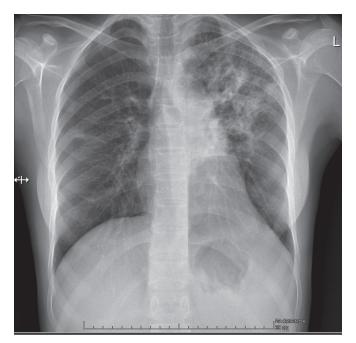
Chest X-ray in the patient before treatment onset
